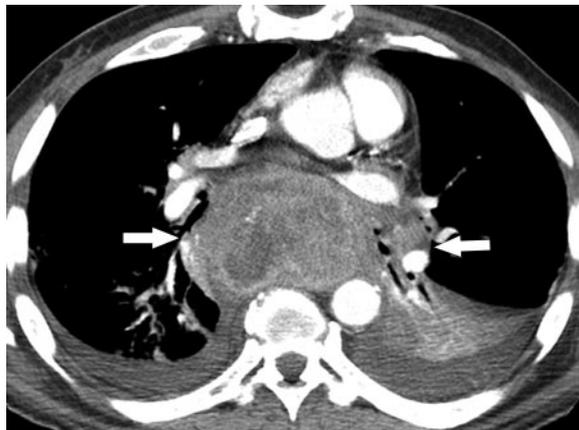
Non-small cell lung cancer in a patient with a 20-year history of crack cocaine abuse. CT scan shows a large, heterogeneous subcarinal and retrocardiac mass with enlarged hilar lymph nodes (arrows).
